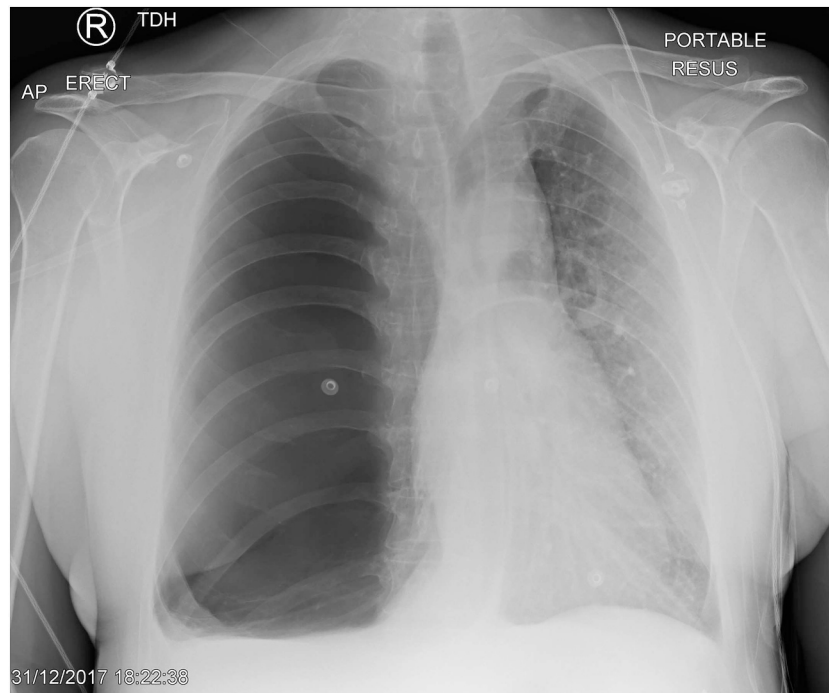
Chest radiograph in 2017 showing large bulla starting to cause mediastinal shift.
